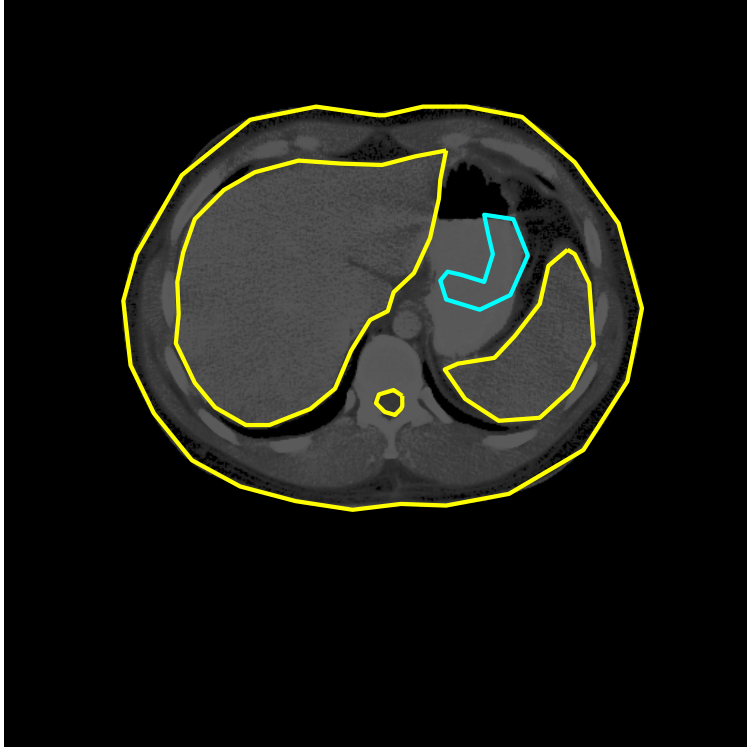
CT image of patient with critical structures and tumor outlined
